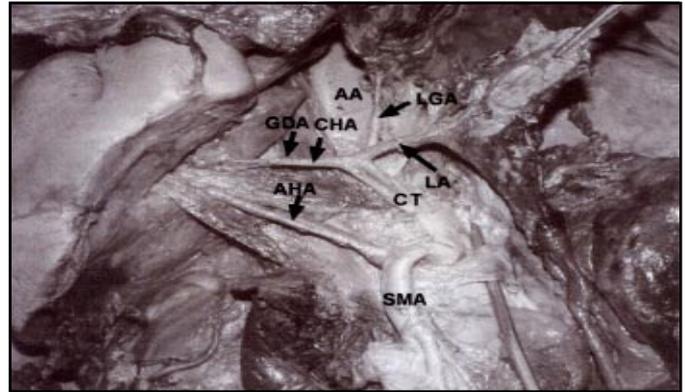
Photograph of the additional hepatic artery (AA - abdominal aorta, CT - celiac trunk, CHA - common hepatic artery, GDA - gastroduodenal artery, LGA - left gastric artery, LA - lienial artery, SMA - superior mesenteric artery, AHA - additional hepatic artery).
